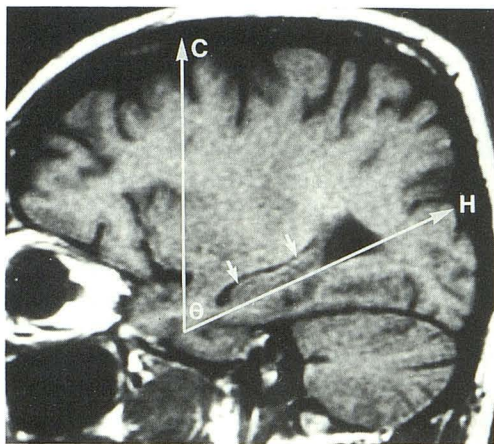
Hippocampal angle on a parasagittal T1-weighted MR image. Hippocampal angle (θ) is formed by interception of plane of coronal MR slice (line C) with plane (line H) parallel to inferior aspect of hippocampal formation (arrows).
